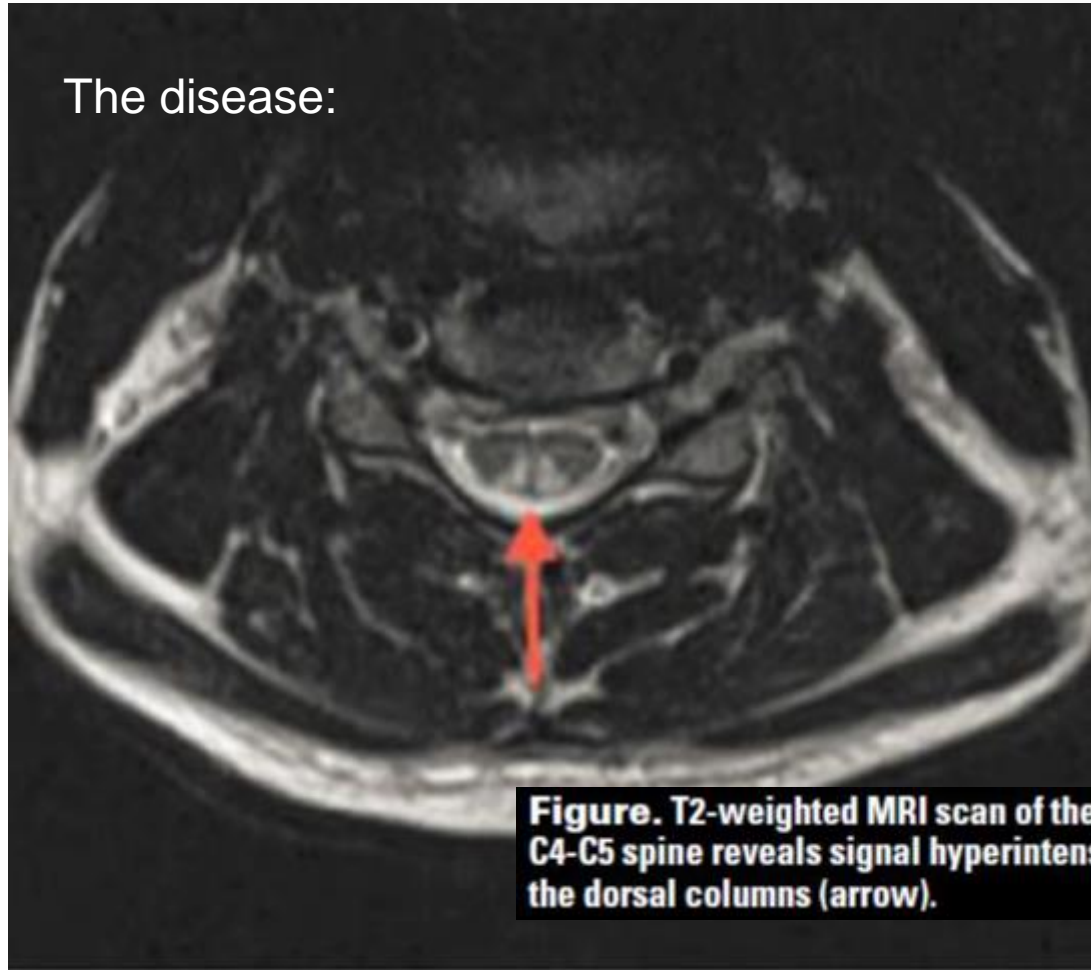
weighted MRI scan of the C4-C5 spine reveals signal hyperintensity in the dorsal columns (arrow).
